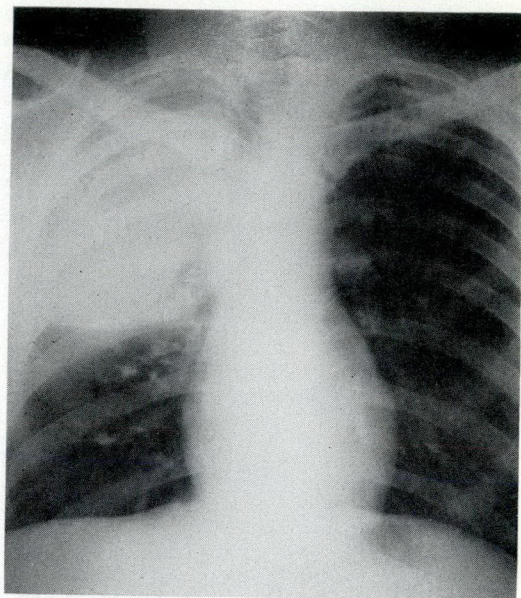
E.W. Chest radiograph September 23, 1950. An extrapleural collapse is maintained by Gomenol oil.
